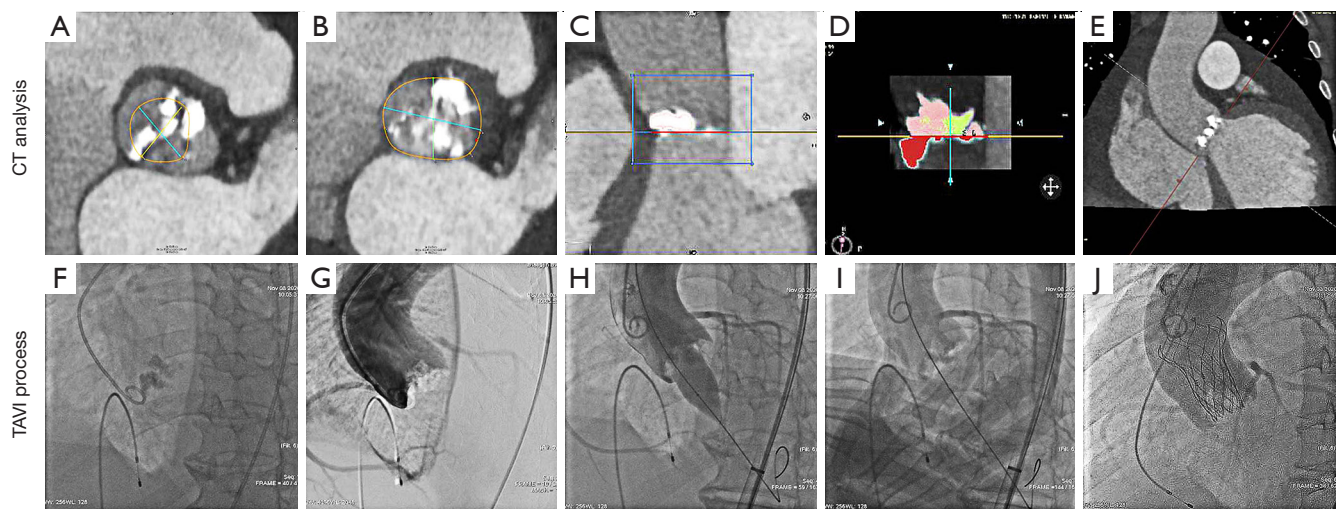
Cardiopulmonary bypass support to circumvent circulatory compromise during the transcatheter aortic valve implantation (TAVI) procedure. A 49-year-old male, whom surgeons considered not to be a suitable candidate for surgery, underwent TAVI with emergency intraoperative cardiopulmonary bypass (CPB) support. He presented with orthopnea and massive pleural effusion. Transthoracic echocardiography indicated severely calcified bicuspid aortic valve stenosis, moderate aortic regurgitation, and moderate to severe mitral regurgitation with a pulmonary arterial systolic pressure of 50 mmHg. Transesophageal echocardiography showed a mean aortic valve gradient of 55 mmHg, a maximum transaortic velocity of 4.5 m/s, and a left ventricular ejection fraction of 28%. The patient suffered from a hemodynamic collapse as a result of ventricular fibrillation after balloon predilation. The images show the patient's aortic root measurement and the entire TAVI procedure. (A) Supra-annular narrowing of the bicuspid valve at 6 mm above the basal ring. (B) The level of the basal ring: the minimum diameter was 28.62 mm, the max diameter was 37.82 mm, and the area was 9.11 cm². (C) Calcium volume of calcification volume (calcification detection was set at 850 Hounsfield units): the aortic valve region calcium was 1,116.0 mm³. (D) The first bicuspid cusp was 797.5 mm², and the second bicuspid cusp was 318.4 mm². (E) Aortic angulation. (F) The pigtail catheter located at the base of the coronary sinus. (G) Aortic root angiography. (H) Recalcitrant ventricular fibrillation occurred after aortic predilation with a 20-mm balloon. (I) Cardiopulmonary resuscitation and femoral arteriovenous intubation were initiated immediately. The valve release assisted by CPB proceeded as follows: suspension of extracorporeal assistance, exsanguination, release, restart of CPB, and defibrillation. The prosthetic valve localization was indicated by calcified plaques of the native valve. (J) Both coronaries were patent, and no perivalvular leak was detected. The patient was weaned from CPB after 61 minutes of support. After the procedure, transesophageal echocardiography indicated that the mean transvalvular gradient was 10 mmHg, the maximum transaortic velocity was 2 m/s, and the effective orifice area was 1.9 cm². (Self-expandable valve: #24 VitaFlow, MicroPort, Shanghai, China).
